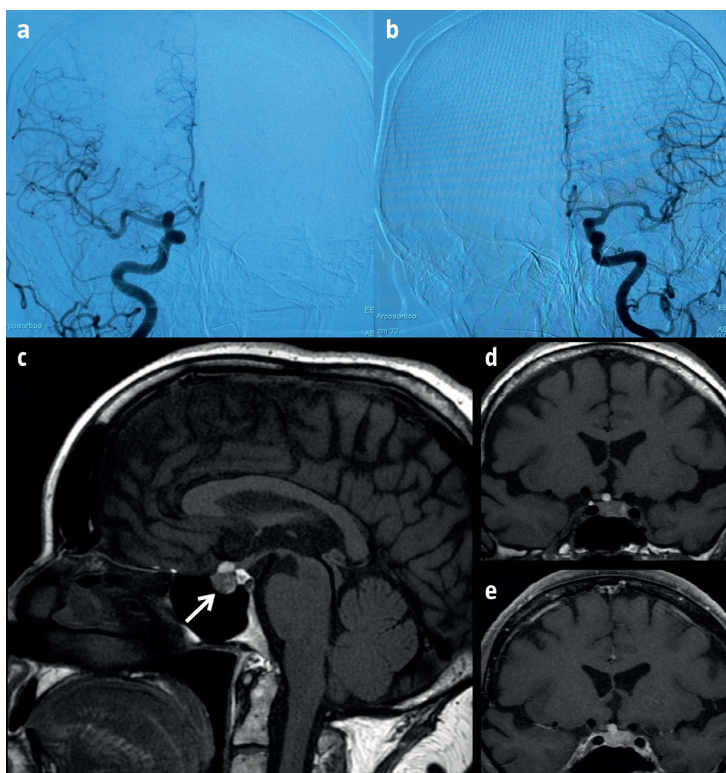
Digital Angiography subtraction. A and b) Posteroanterior projection showing no evidence of aneurysm. Thin-slice pituitary magnetic resonance imaging; c) Sagittal projection demonstrating a lesion (white arrow) with hypersignal on T₁-weighted image in the projection of the pituitary stalk adjacent to the A2 segments of the anterior cerebral arteries; d and e) Coronal projection before and after contrast enhancement showing hemorrhagic adenoma.
